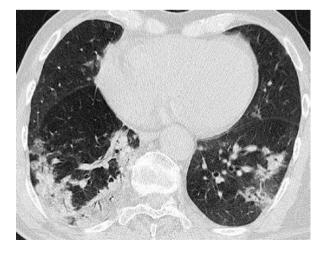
(a) Organising pneumonia in systemic connective tissue disease: a CT scan from 5/2015 multiple consolidations of the pulmonary parenchyma bilaterally and peripherally. (b) Organising pneumonia in systemic connective tissue disease the same patient as previous scan: CT scan from 2/2016: clear regression of previously apparent consolidations, with new consolidations in the left upper lobe located by the interlobar fissure
